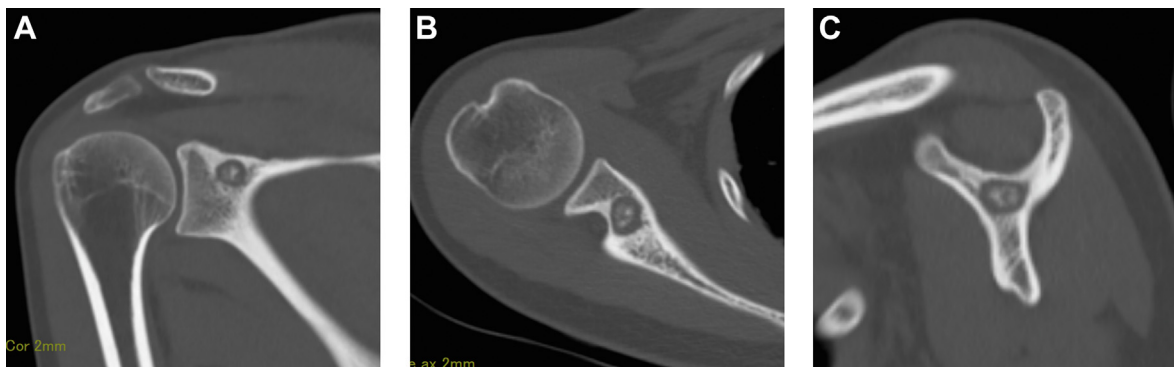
CT: (A), coronal view; (B), axial view; and (C), sagittal view. The neck of the scapular spine, 10 mm medial to the glenoid fossa, and sagittal section show a nidus image approximately 10 mm in diameter in the body of the scapula at the base of the scapular spine and coracoid process. CT, computed tomography.
